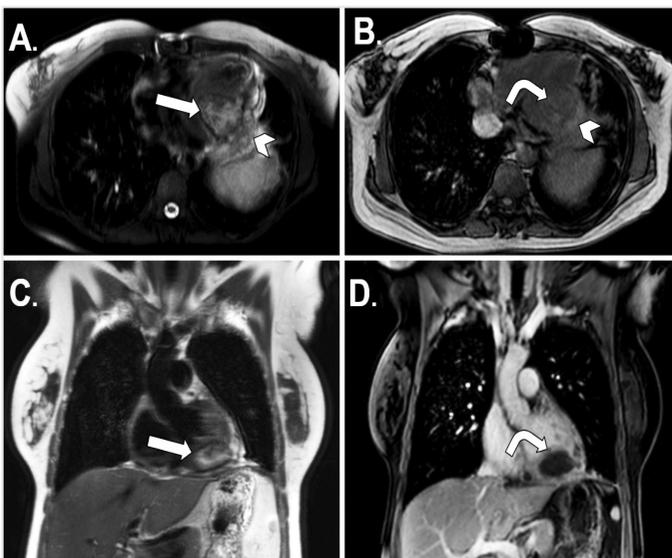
(Patient 1*) The cyst is heterogeneous and hyperintense on the axial and coronal T2-weighted images (arrow, A and C) and heterogeneous and hyperintense on precontrast axial T2-weighted image (curved arrow, B). On coronal T1-weighted, delayed-phase cardiac images after contrast injection, peripheral rim enhancement (curved arrow, D) is seen around the cyst. Extracardiac involvement of the cyst is also seen on the axial T1- and T2-weighted images (arrowheads, A, B)
